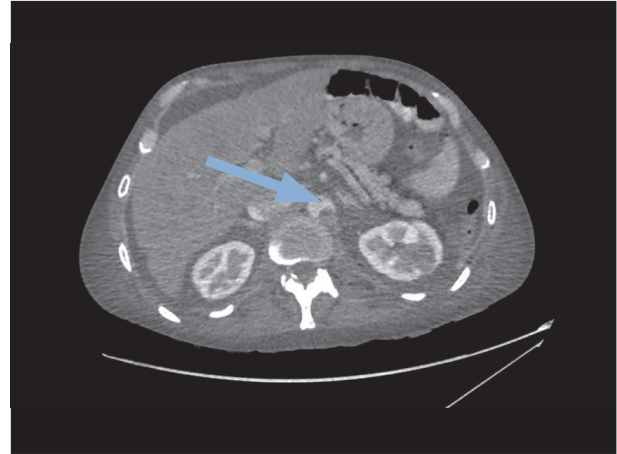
CT abdomen demonstrating intra-aortic thrombus (arrow)
